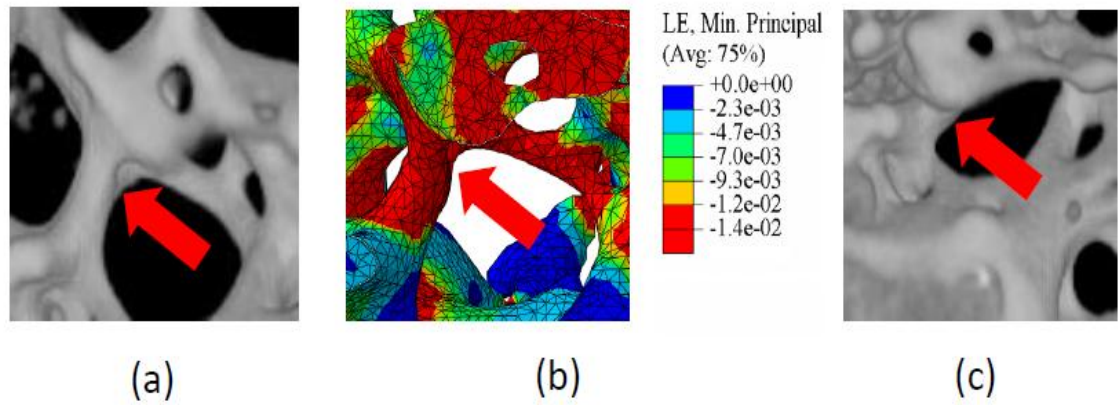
11: (a) CT image of a typical bone-cement interface sub-volume (Fig. 4.7a, BC01). (b) The local predicted minimum principal strain distribution of the same sub-volume from the FE model and (c) the damage sustained at the failure state during the experiment (Fig. 4.7c, BC01). The high local compressive strain predicted (b) may explain the local buckling damage (c), as indicated by the arrows (Tozzi et al., 2012b).
